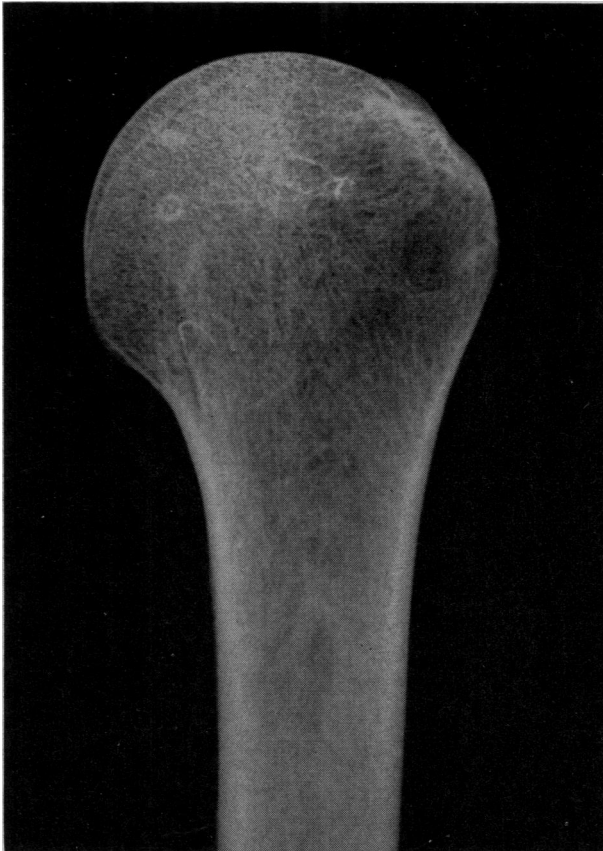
Anteroposterior roentgenogram of upper humerus. A cavity can be seen in the greater tuberosity, but the amount of cancellous bone in the shaft cannot be estimated. The epiphyseal plate is not identifiable.
